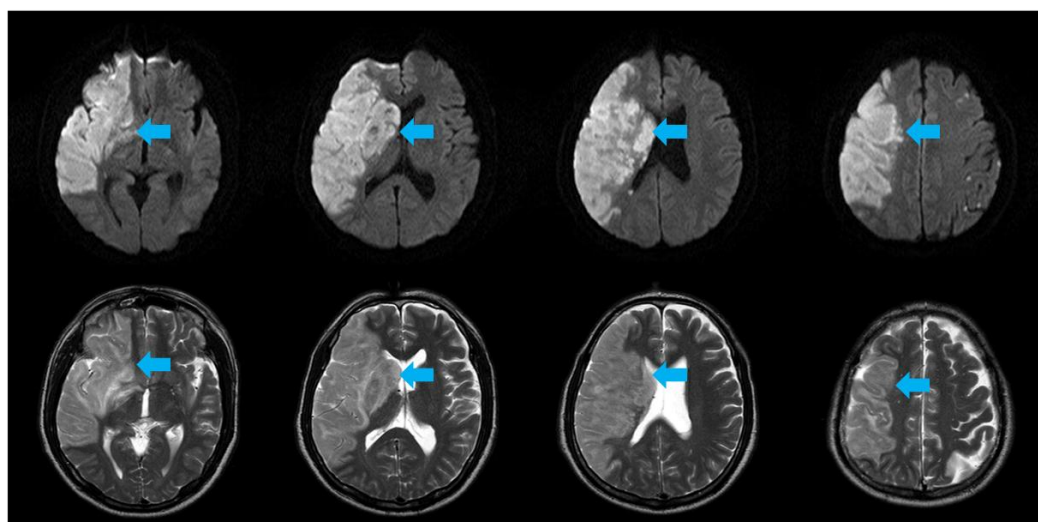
Diffusion-weighted (upper panel) and T2-weighted (lower panel) magnetic resonance images of a 55-year-old male patient with a complete middle cerebral artery territory infarct (blue arrows).
